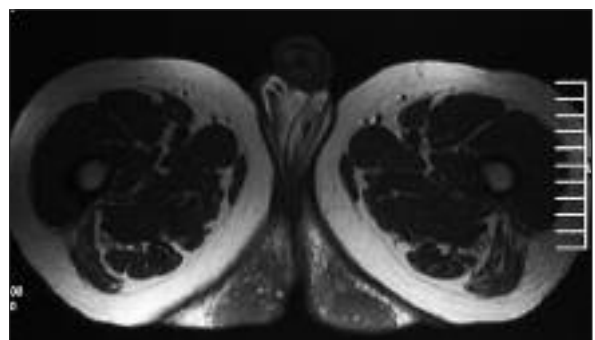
MRI of the case: T1-weighted axial image shows masses in subcutaneous fat tissue of intergluteal region symmetrically and bilaterally. The signal intensity is low compared to subcutaneous fat tissue.
